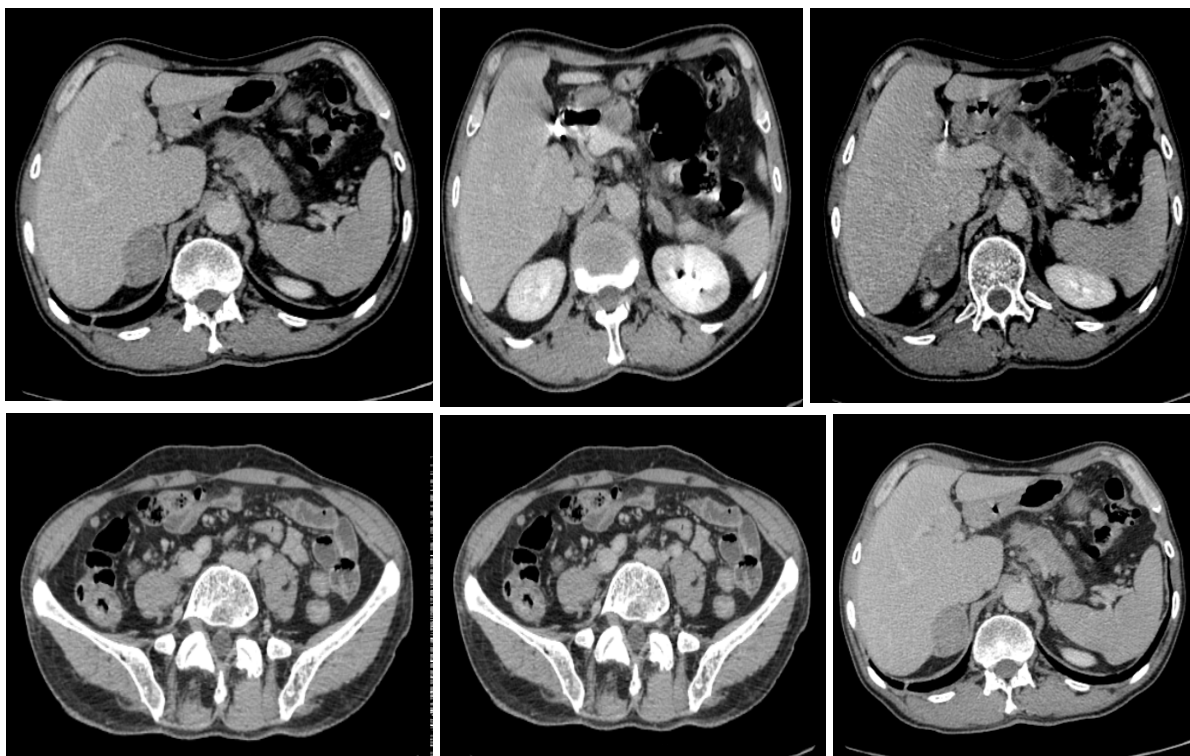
Abdominopelvic CT scan after PDC injection at venous time showing bilateral adrenal lesions (yellow star), heterogeneously enhanced after contrast. Pancreatic body and isthmus lesions, heterogeneously nodular (blue arrow) peripancreatic and perigastric adenopathies (yellow arrow) and peritoneal nodules at the level of the GPC (red arrow).
